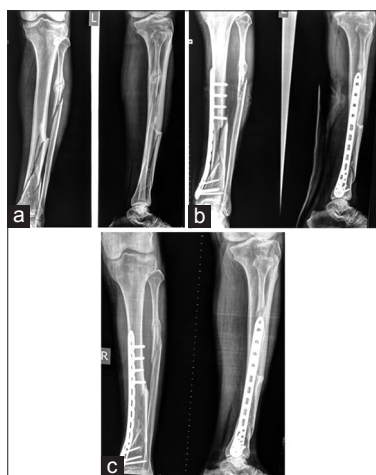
(a) Pre-operative xray of distal metadiaphyseal tibia fracture. (b): Follow up xray. (c):United fracture of distal metadiaphyseal tibia
